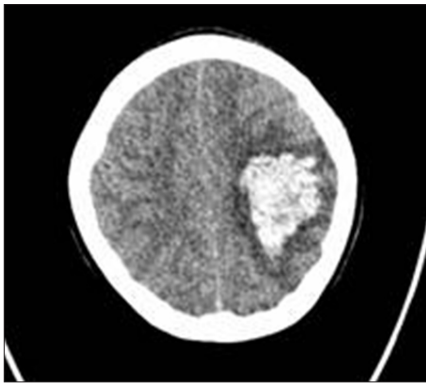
CT scan showed subcortical hematoma in left parietal area
